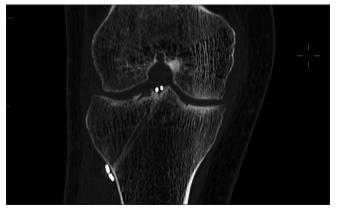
Computed tomography scan of knee joint showing bony union at 3 months
